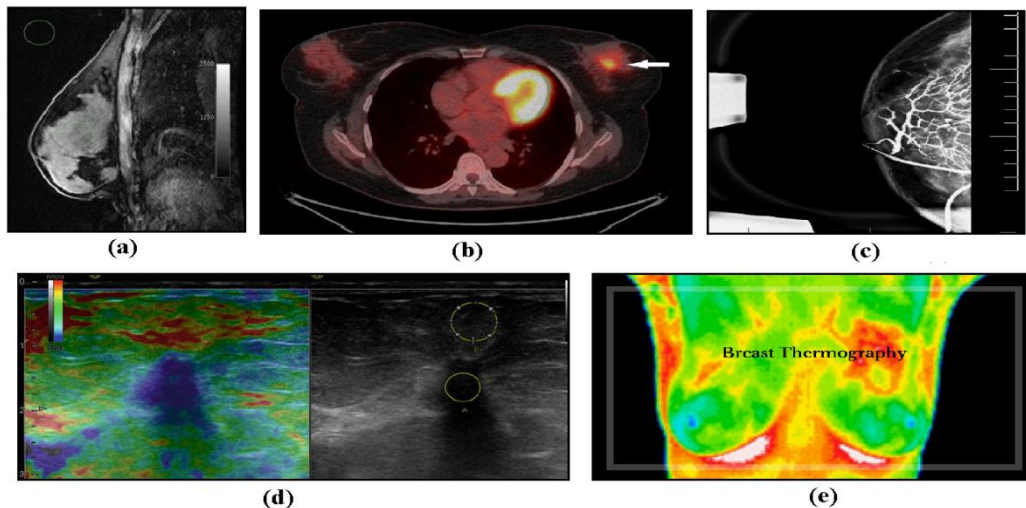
Photographs of (a) Breast Magnetic Resonance Imaging (MRI), (b) Positron Emission Tomography (PET), (c) ductography, (d) elastography, and (e) thermography
